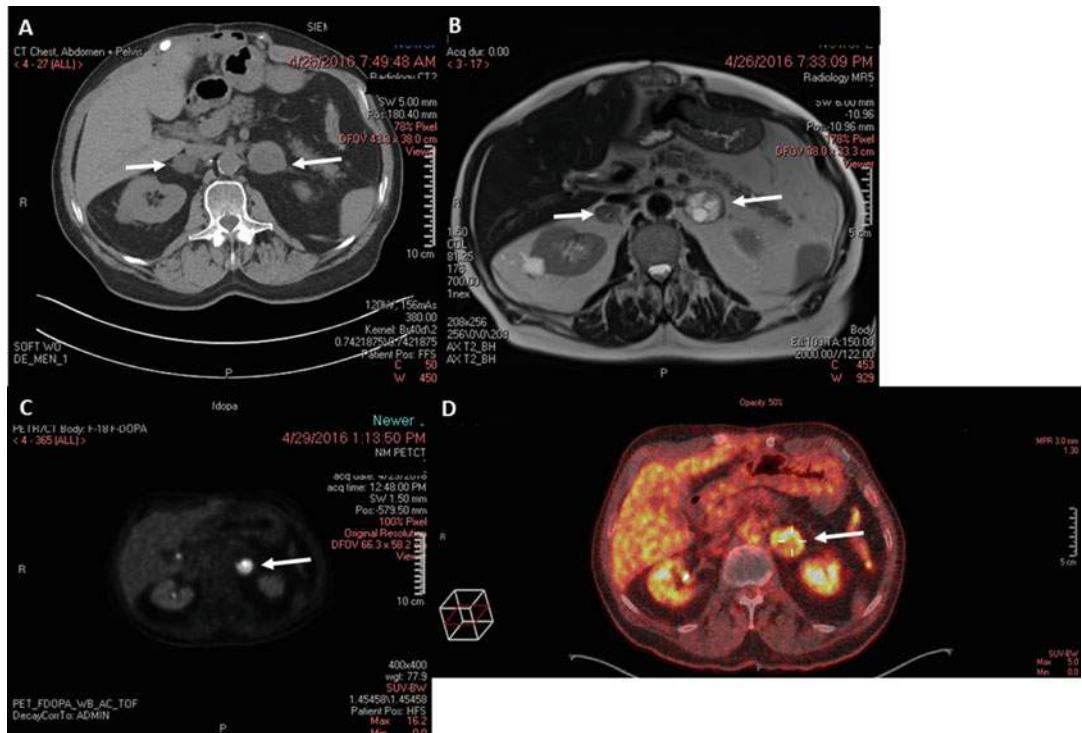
Multimodal imaging results in a patient found to have bilateral adrenal masses in the setting of multiple endocrine neoplasia type 1 and with biochemical evidence of pheochromocytoma. (a) Computed tomography scan shows bilateral adrenal neoplasms. The right adrenal tumor has a lower Hounsfield unit than the left adrenal mass. (b) Magnetic resonance imaging shows bilateral adrenal masses but the left adrenal mass enhances on T2-weighted image which is suggestive of a pheochromocytoma. (c) F-18F DOPA imaging shows uptake in the left adrenal gland only, which is consistent with a pheochromocytoma. (d) 18 F FDG PET/CT imaging show increased uptake in the left adrenal gland but not right adrenal mass which is also consistent with a pheochromocytoma in the left adrenal gland. The right adrenal tumor was consistent with a nonfunctioning adrenocortical tumor. The left adrenal tumor was consistent with a pheochromocytoma on pathologic examination
